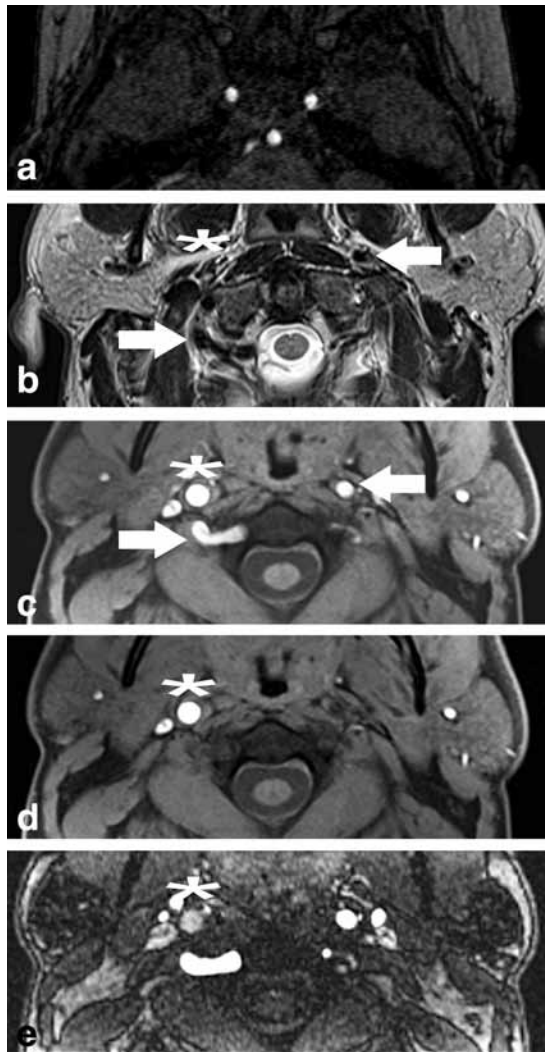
Axial (a) 3D TOF in a normal patient and (b) T2, (c) 3D TOF without and (d) with an inferiorly placed spatial saturation pulse, and (e) contrast-enhanced MRA images in a patient with a right carotid occlusion. All noncontrast images were acquired with a superiorly placed saturation band to suppress venous signal. Normal bilateral internal carotid and vertebral artery (the right vertebral artery is dominant) signal intensity is seen in the (a) normal patient. Normal flow voids are seen in the right vertebral and left carotid (white arrows) arteries on the (b) T2-weighted images with corresponding high intravascular signal demonstrated in these areas on the (c) TOF images in the patient with a right carotid occlusion. On the (c) TOF images, the high signal within the right internal carotid artery (asterisk) could easily be mistaken for normal intravascular flow. The right internal carotid artery flow void is absent (asterisk) on the (b) T2-weighted image. With application of an additional (c) inferiorly placed spatial saturation pulse, there is drop-out of intravascular signal in the left carotid and bilateral vertebral arteries with persistent high signal within the occluded right internal carotid artery (asterisk). This high signal is due to the short T1 of deoxyhemoglobin found in thrombus. On the contrast-enhanced images, this thrombus is demonstrated as relative hypointensity relative to the enhancing left carotid artery.
